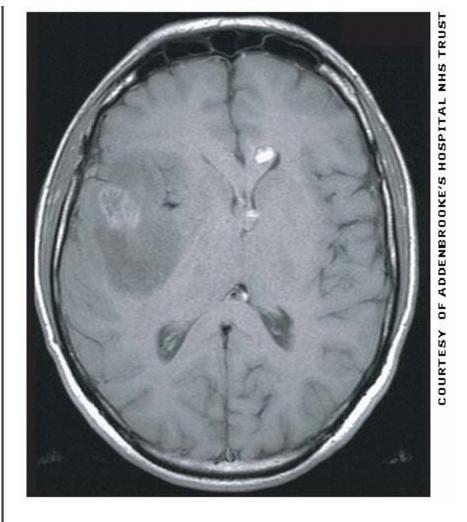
Axial T1 weighted MRI of the brain post IV gadolinium. In the right tempro-parietal region there is an area of low signal with a more central area of high signal. This is causing mass effect with effacement of the sulci and adjacent right frontal horn of the lateral ventricle. There is midline shift.
